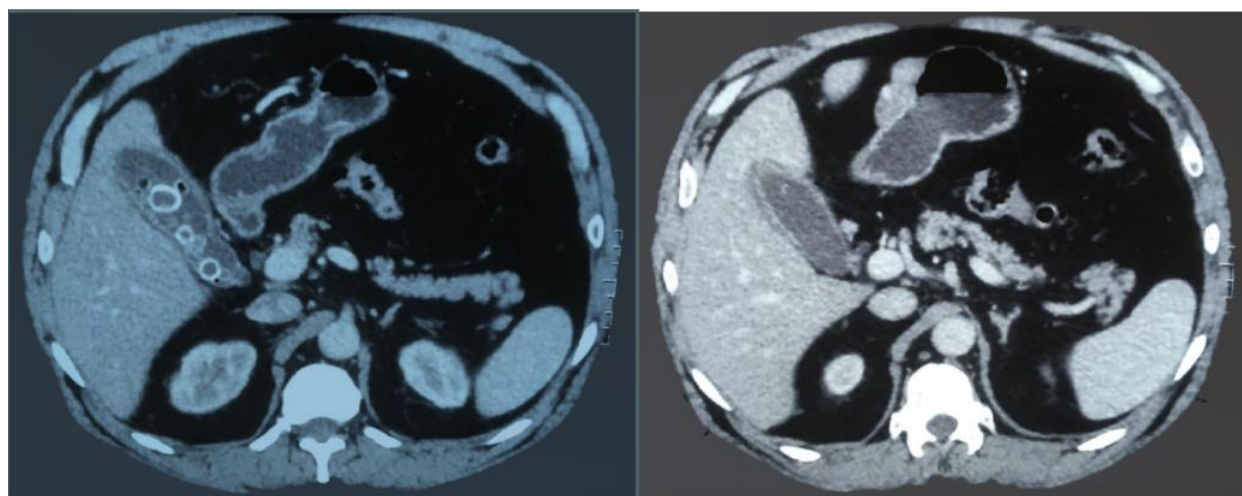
Axial abdominal computed tomography showing lithiasic cholecystitis.
